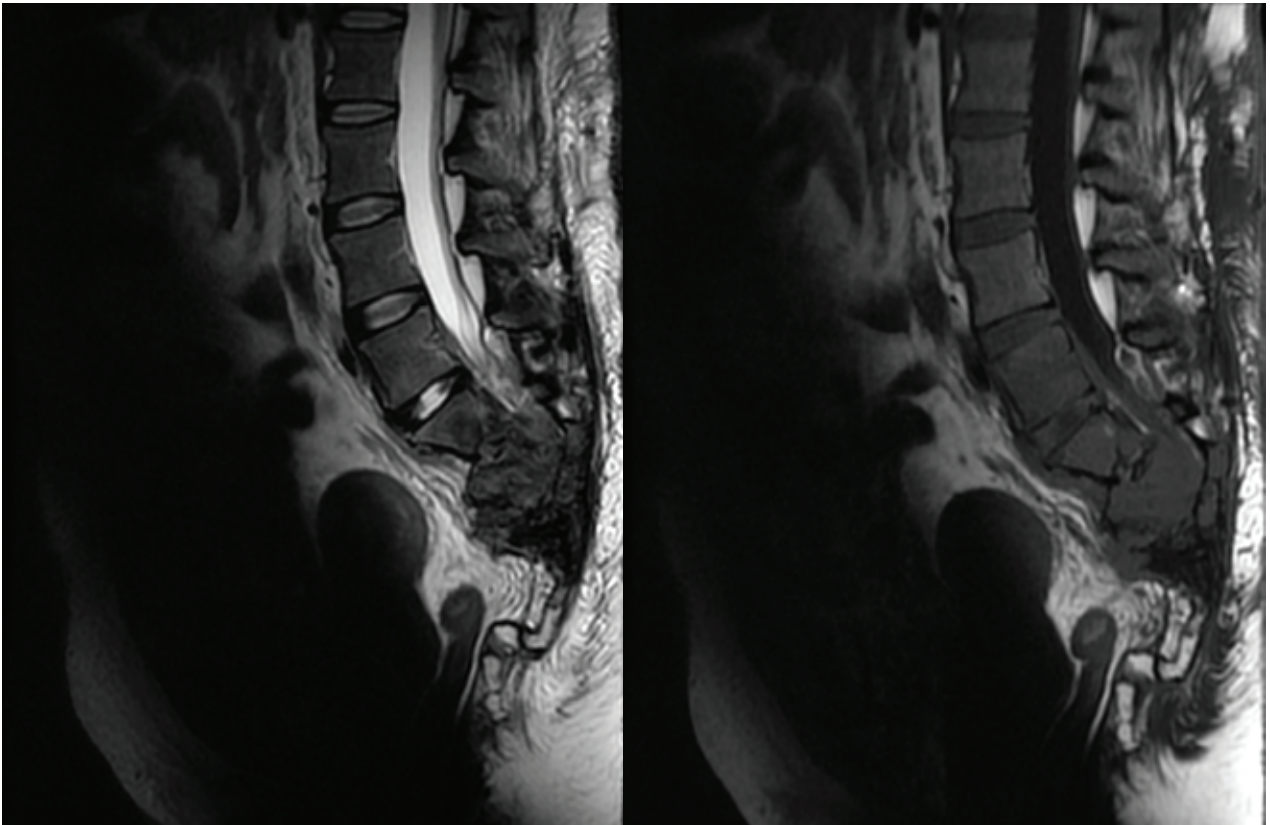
A) Sagittal T2-weighted fast spin-echo MR image shows sacral involvement of mass with anterior and posterior soft-tissue extension and heterogeneous signal intensity. B) Sagittal T1-weighted MR image shows the tumoral mass with homogeneous low signal intensity.
